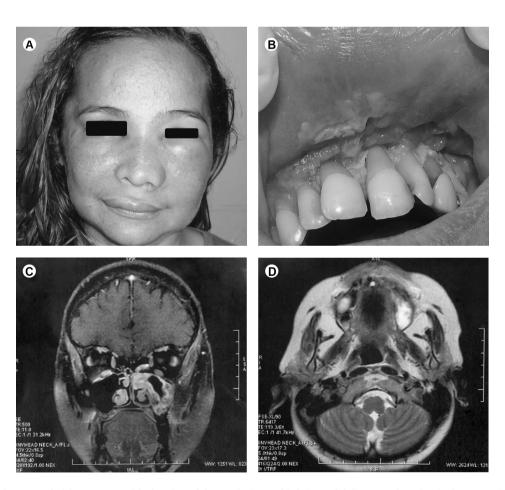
A: Erythematous facial asymmetry with elevation of the nasal wing and inferior eyelid. B: Large ulceration in the upper gingiva and buccal mucosa. C: Coronal and D: axial magnetic resonance image showing the involvement of the nasal cavity, nasal sinus and the preservation of the palate.
